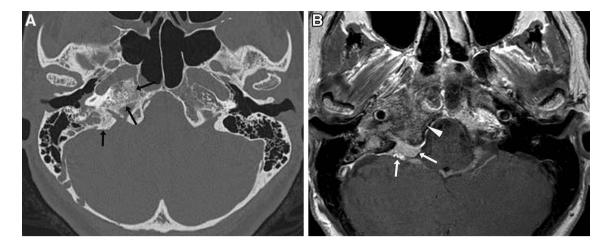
Cerebellopontine angle cistern/jugular foramen meningioma. a Axial CT image in bone algorithm shows a mixed permeative/sclerotic/hyperostotic appearance of the petrous temporal bone where it abuts the meningioma (black arrows). b Axial post-contrast
